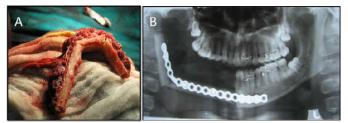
A. Harvested vascularized fibula graft. B.Radiograph of mandible with vascularized graft in situ.
